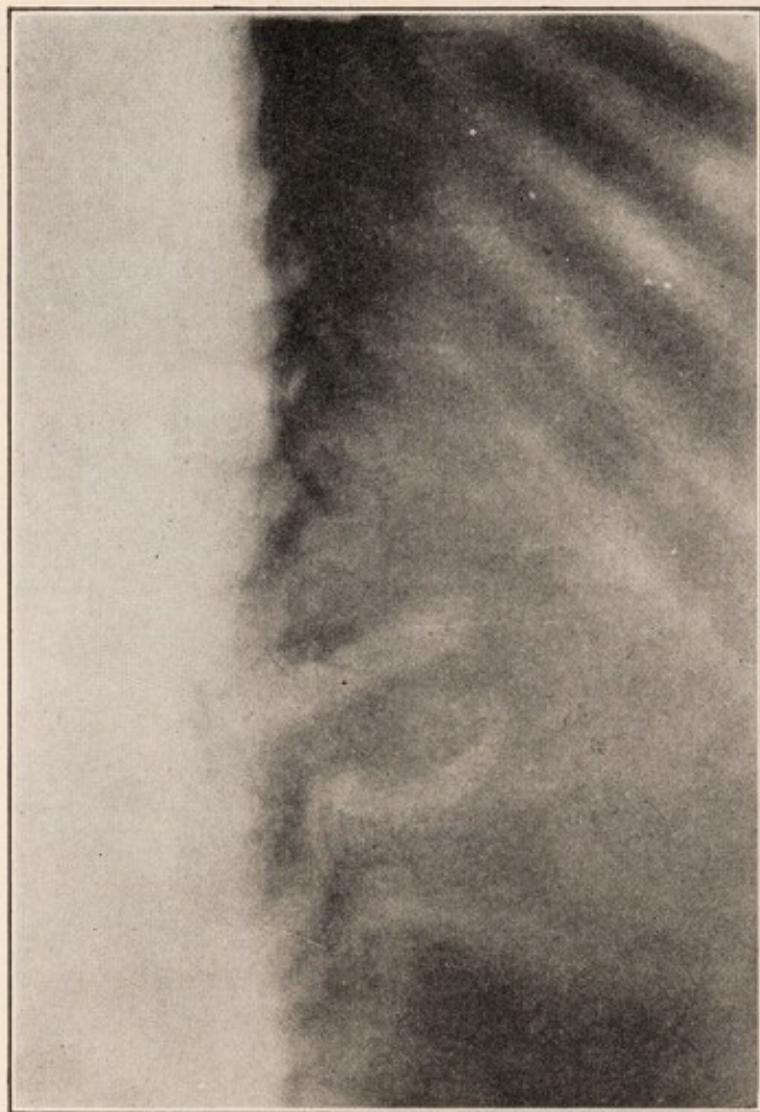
X-ray of fracture dislocation of the dorso-lumbar spine, sensory and motor paralysis with recovery. Lateral view showing over-riding of the first and second lumbar vertebrae.
